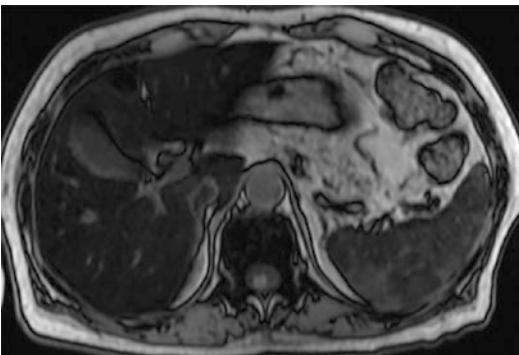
Axial T1-weighted out-of-phase imaging through the liver demonstrates relatively increased signal of the liver and spleen relative to the in-phase imaging in Fig. 8.7
